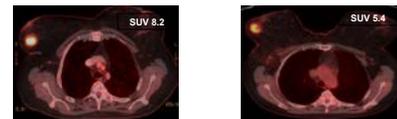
Patient A with decreased SUV (SUV 8.2 and SUV 5.4) after single Bev dose
